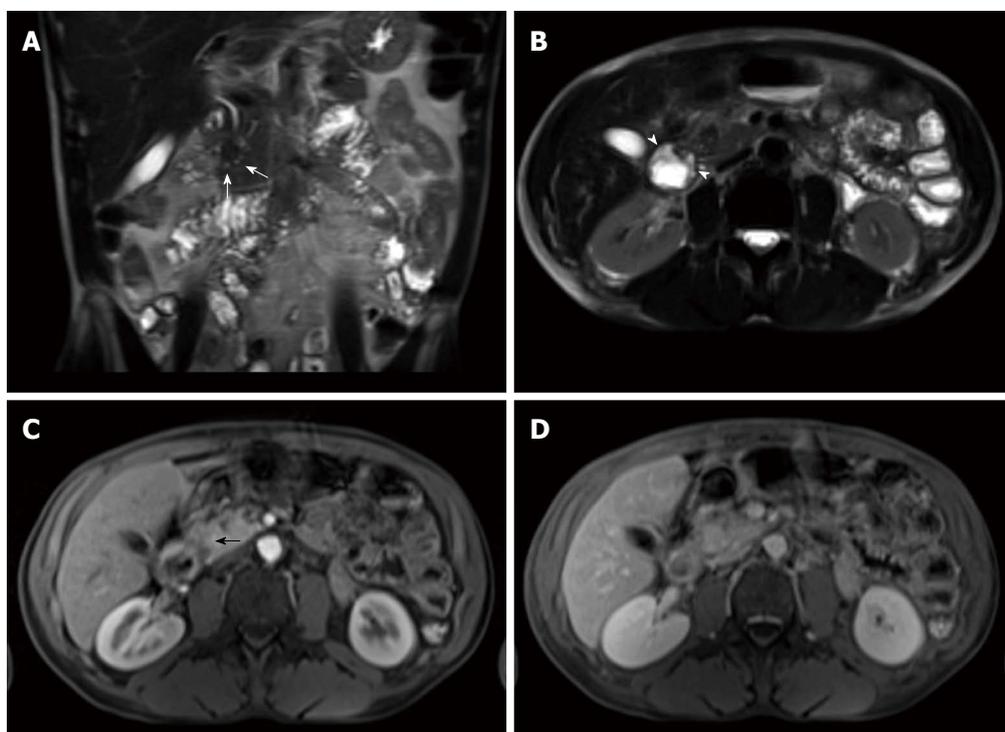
Segmental form groove pancreatitis. Coronal (A) and axial (B) single-shot turbo spin-echo T2-weighted (HASTE) images with fat-suppression. Axial post-Gadolinium 3D-GRE T1-weighted images with fat-suppression during the hepatic arterial-dominant (C) and interstitial phases (D). There is mild duodenal thickening and edema (arrowheads) (A, B) associated with a sheet-like mass in the pancreaticoduodenal groove that extends to the pancreatic head and demonstrates decreased T1 signal pre-contrast (not shown), slightly decreased T2 signal with tiny cystic changes (white arrows) (A, B), early arterial hypo-enhancement (black arrow) (C) and progressive enhancement on the subsequent delayed images (D) due to fibrosis, in keeping with segmental form groove pancreatitis.
